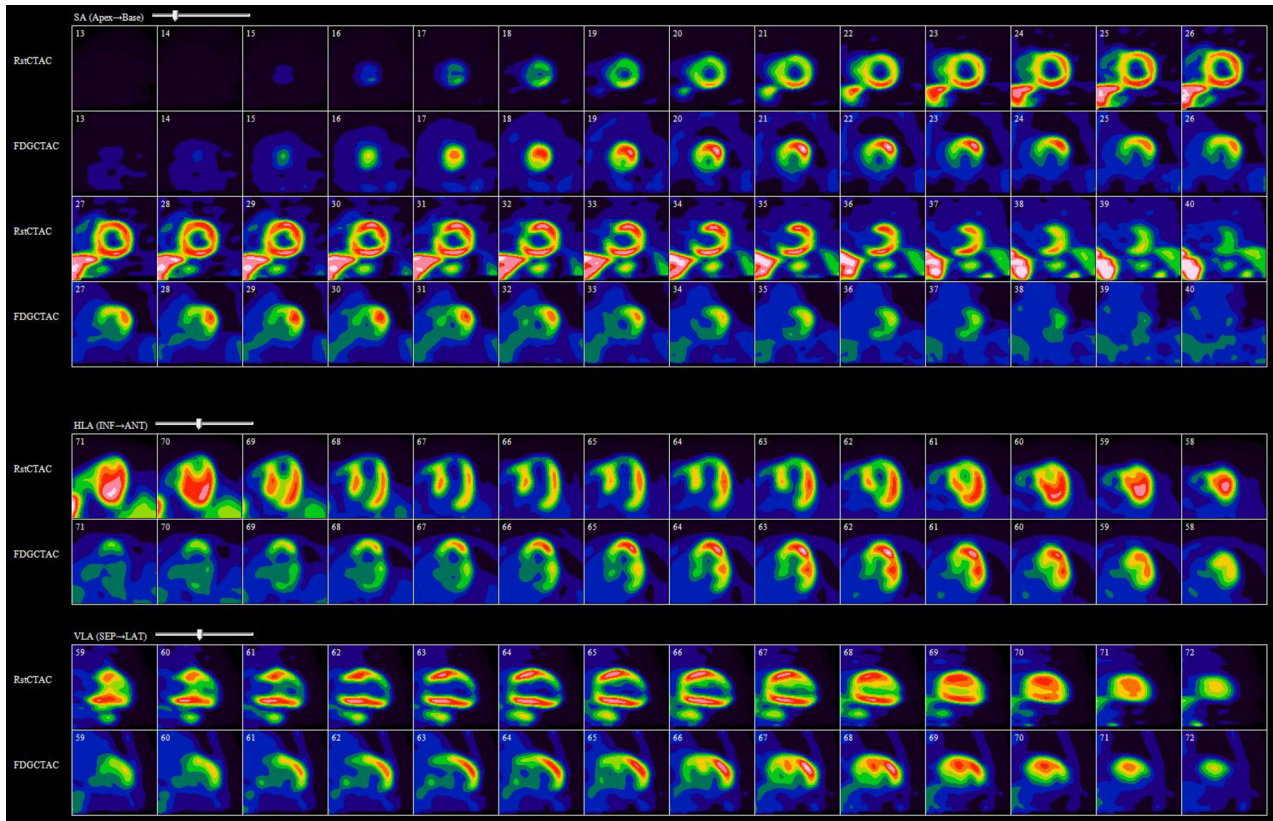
Viability study demonstrating a large area of hibernating myocardium in the LAD territory. Rest PET perfusion imaging using $^{13}\text{N-NH}_3$ (*upper row*) shows a moderate reduction in perfusion in the distal anterior, antero-septal, and septal walls as well as the apex. $^{18}\text{F-FDG}$ PET (*bottom row*) shows a corresponding area of increased glucose metabolism in the same territory.
